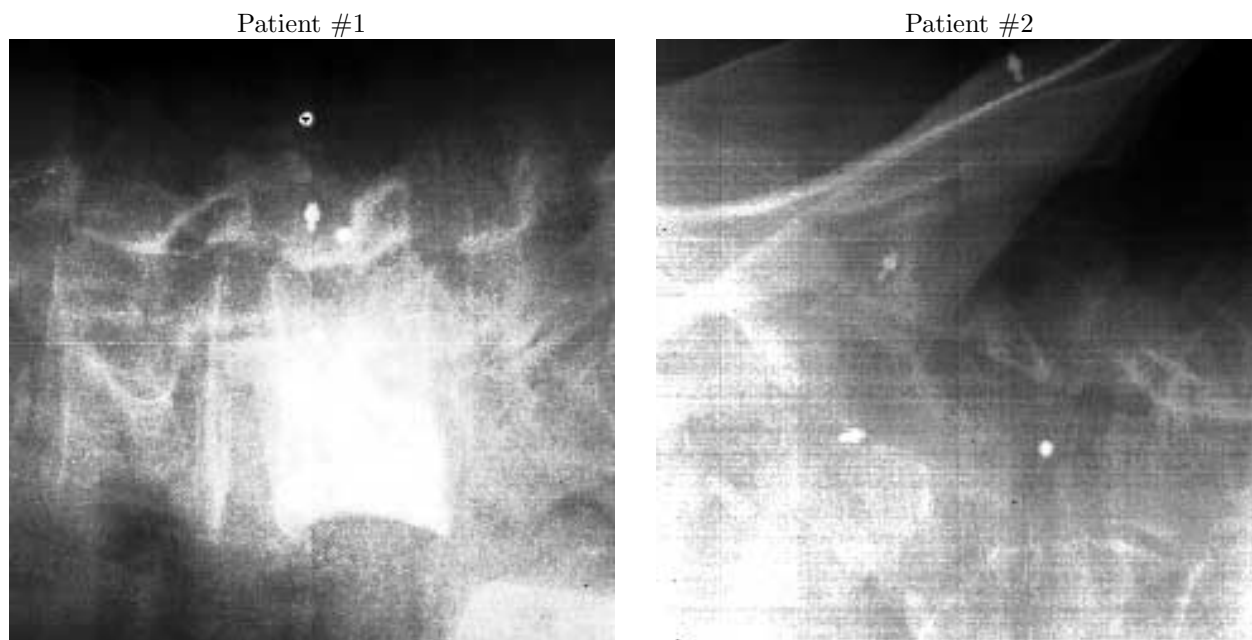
X-ray projection images acquired using amorphous silicon flat panel detectors. The image from patient #1 (*left*) shows part of the lumbar spine; one of the vertebrae has previously been filled with (radio-opaque) bone cement. The image from patient #2 (*right*) shows part of the pelvic bone. Each image contains three implanted BB's, which were used to determine the gold standard transformation between the 2-D projections and the 3-D CT image. The original image resolution was 0.1275 mm pixel size, but the images were resampled to 0.51 mm pixel size for increased SNR and more efficient processing. The field of view is 120×120 mm (240×240 pixels). The distance of the ray source from the center of the projection plane was 329 cm.
